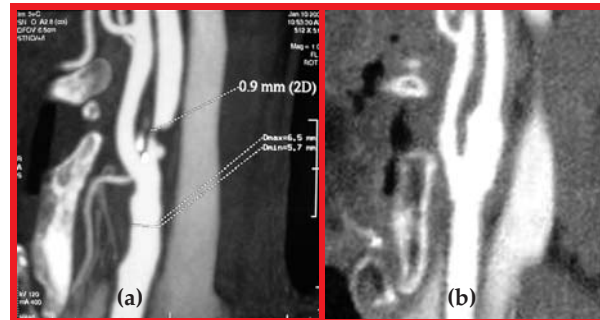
(a) CT angiogram showed typical proximal severe internal carotid stenosis; (b) CT angiogram showed satisfactory revascularisation after CEA.
